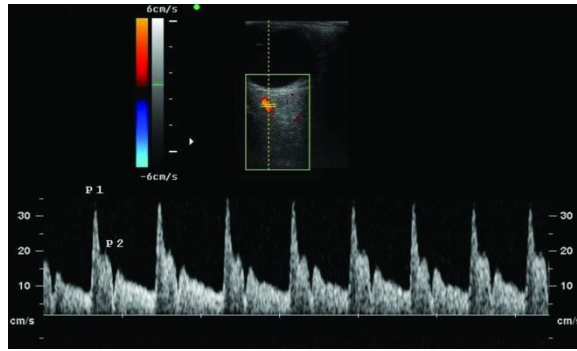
Doppler velocimetry of the ophthalmic artery in a normal pregnant woman ([www.jultrasoundmed.org](http://www.jultrasoundmed.org))
